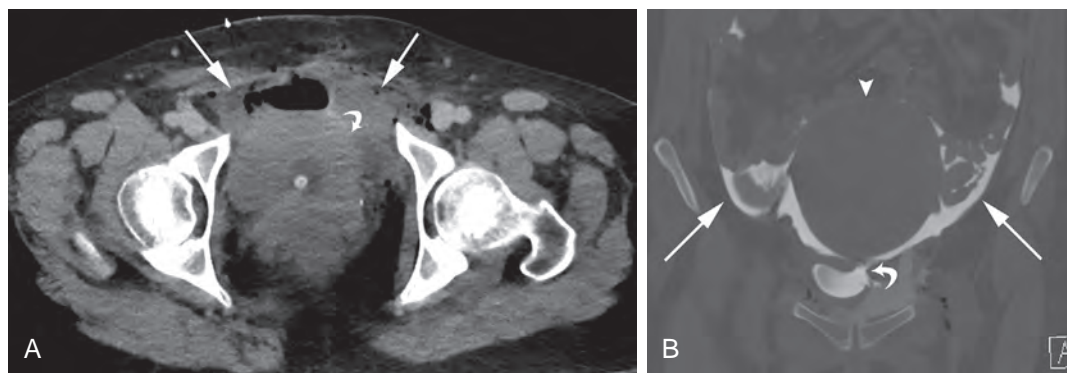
Intraperitoneal bladder rupture. A 33-year-old woman after penetrating pelvic injury. A. Contrast-enhanced CT scan reveals hematoma and air in the pelvis bilaterally (*straight white arrows*). A partially decompressed urinary bladder is seen containing a Foley catheter (*curved arrow*). B. Because of extensive hemorrhage in the pelvis, CT cystography was performed, and coronal reformatted images reveal extravasated contrast outlining bowel loops in the intraperitoneal space (*straight white arrows*). Note the approximate site of rupture at the left lateral bladder wall (*curved arrow*). Notice is made of an enlarged postpartum uterus in the central part of the image (*arrowhead*).
